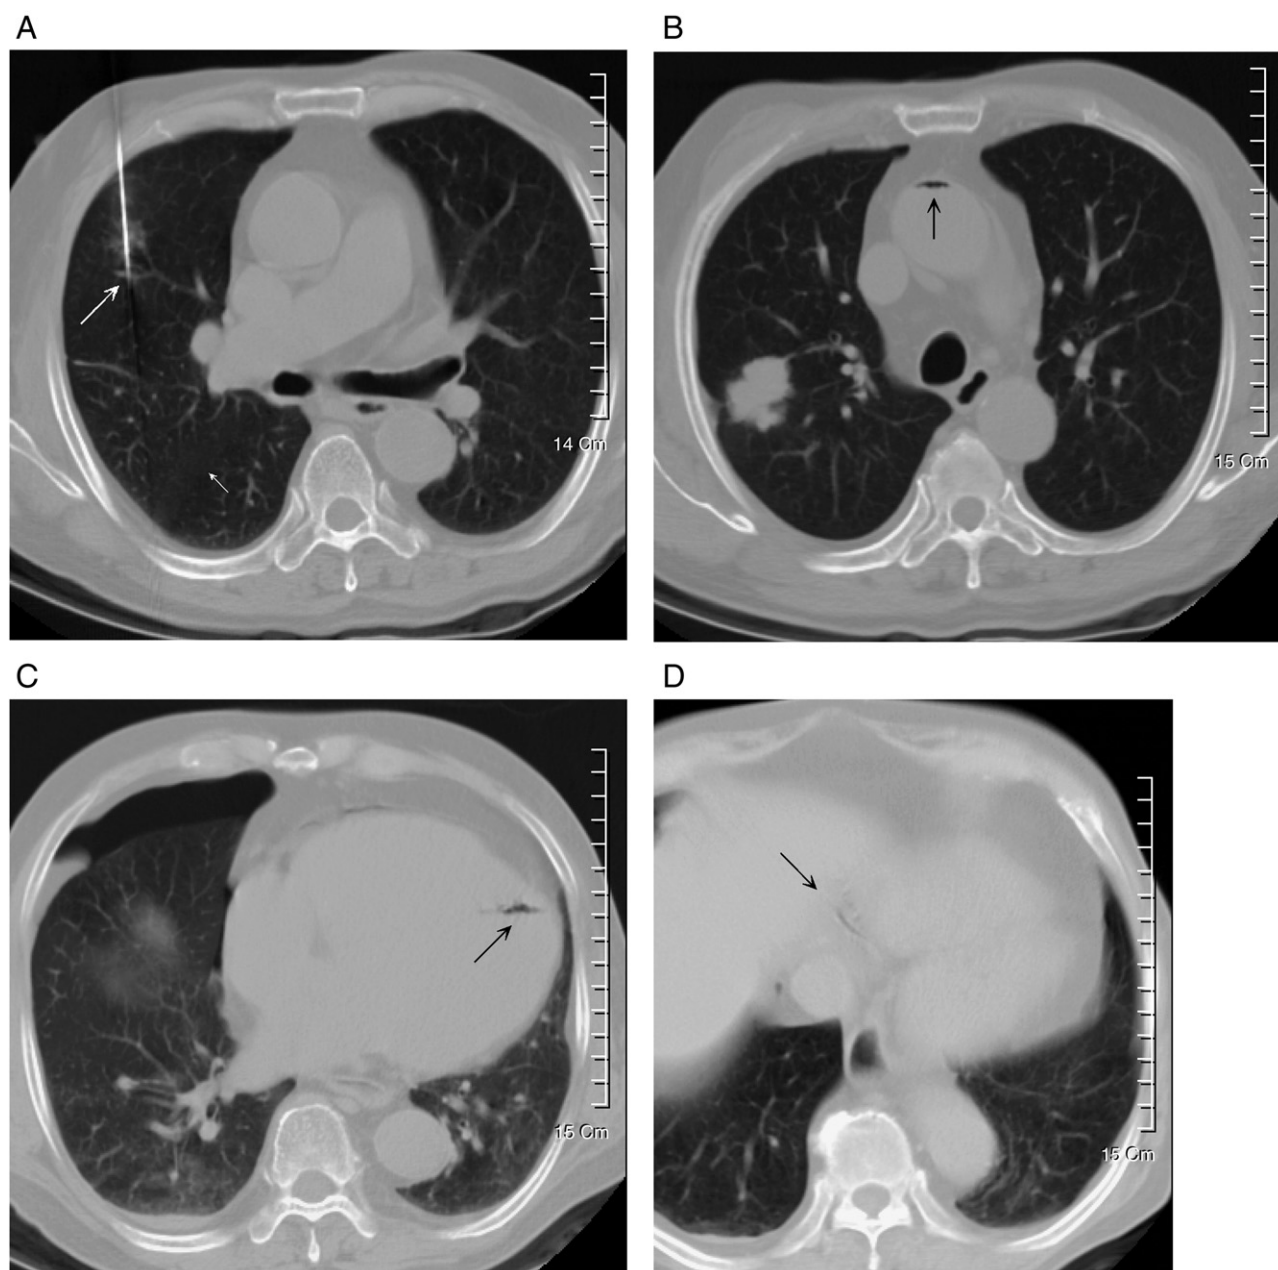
Case 1. A CT-guided needle biopsy was performed from an anterior approach to avoid puncturing through the major fissure (A, small arrow). Note the needle tip at a pulmonary vein during the procedure (A, large arrow). The postprocedure CT scan revealed mild left pneumothorax; regional pulmonary hemorrhage; and the presence of air in the ascending aorta, left ventricle, and right coronary artery [arrows in (B)–(D)].
